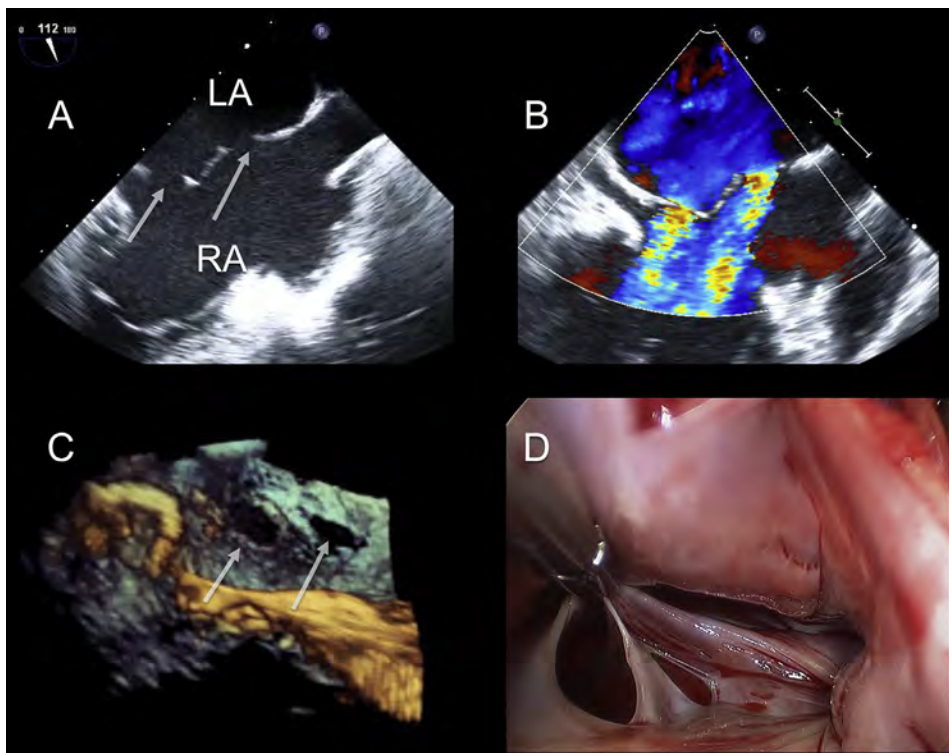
Three-dimensional TEE of one medium and one small ostium secundum ASDs (white arrows). (A) Bicaval view demonstrating two discrete ASDs. (B) Bicaval view with color Doppler demonstrating two discrete left to right shunts. (C) Zoom acquisition of both ASDs en face from RA perspective. (D) Minimally invasive surgical repair demonstrating identical pathologic findings to 3D TEE.
